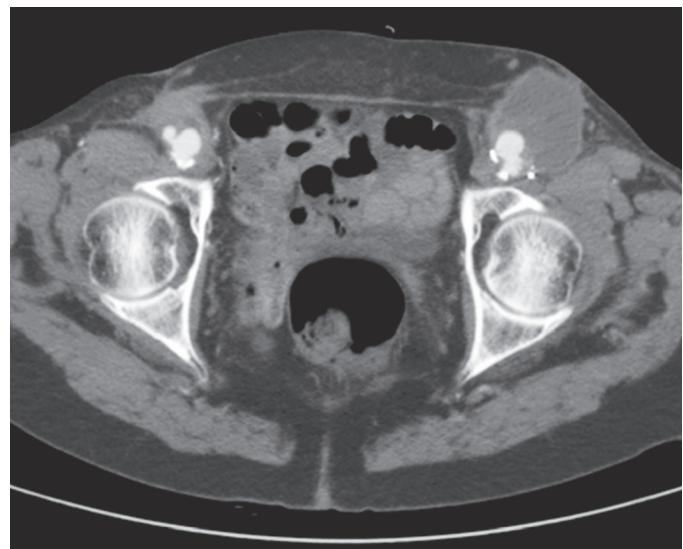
Axial computed tomographic image of bilateral femoral anastomotic aneurysm after aortobifemoral bypass.
